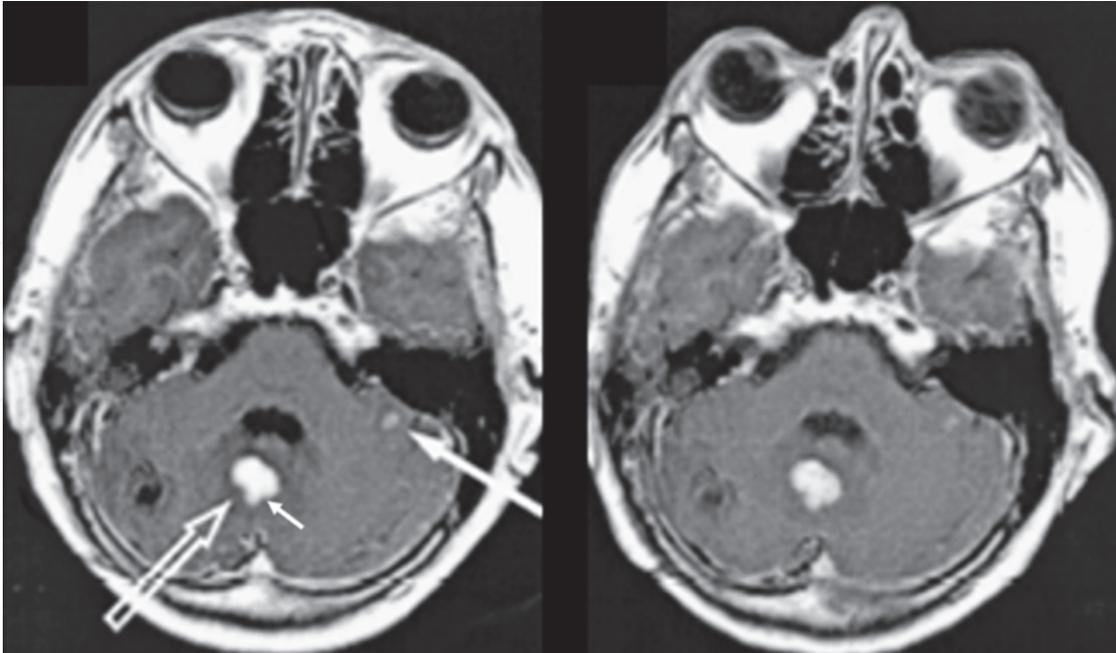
A patient with multiple cerebral metastases, gadobenate dimeglumine-enhanced MRI is able to show additional metastases in the left cerebellar hemisphere (left) and a larger appearance of the lesion in projection of the midline (from Knopp et al. [12]). High relaxivity enhanced images shown on the left and the comparator-enhanced image on the right.
